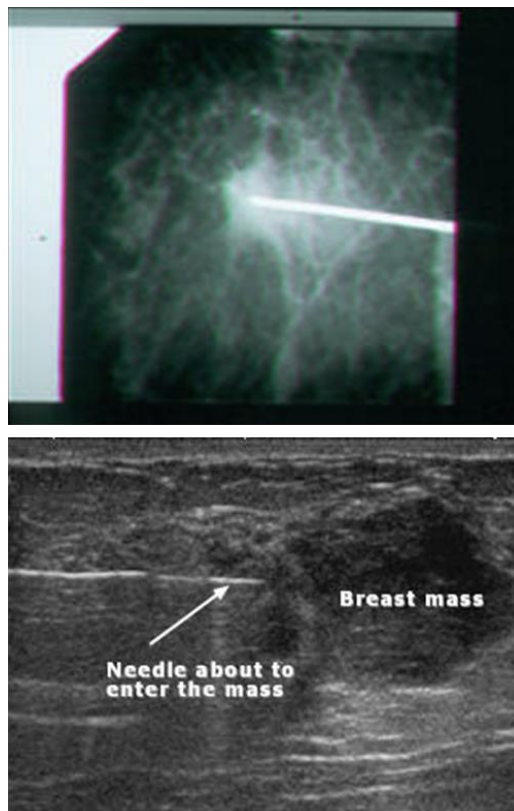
Guided breast biopsies. The top image shows a stereotactic biopsy [32], where the bright rod is the needle and the white mass is the suspicious region. The bottom image shows an ultrasound-guided biopsy [33].
